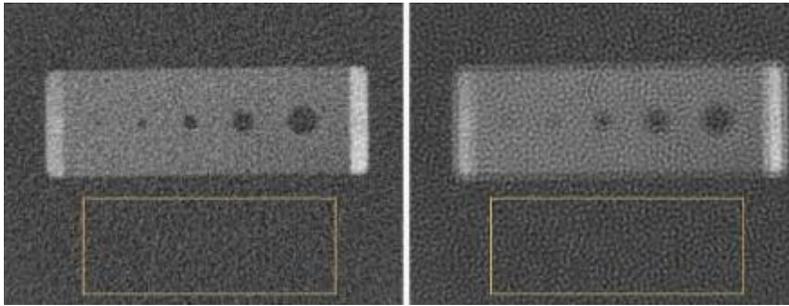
Two CT images of a test object with identical standard deviation and different noise appearance (Bushberg, Seibert, Leidholdt, & Boone, 2012).
